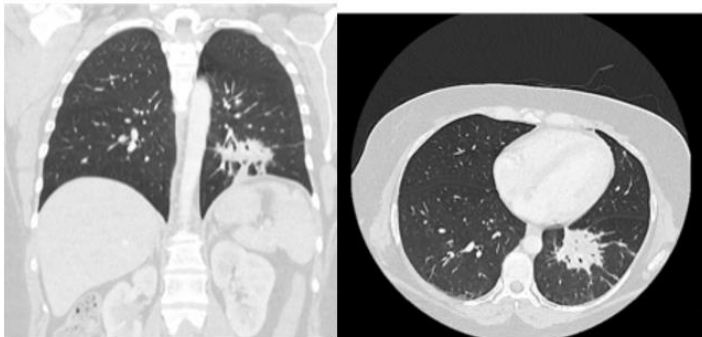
Follow-up CT Chest, Abdomen, Pelvis and Neck showing persistent, unchanged in size, lesion in the left lower lobe.
